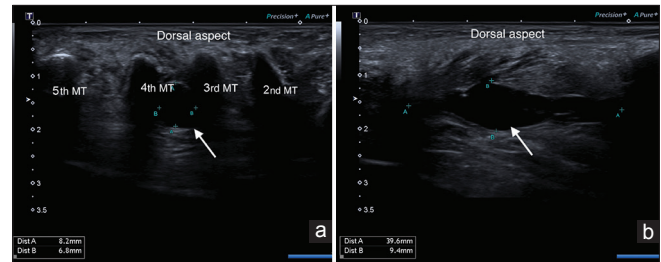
Ultrasound images showing (a) transverse view and (b) longitudinal view of the right dorsal foot (MT: Metatarsal bone, arrow: the lesion)
